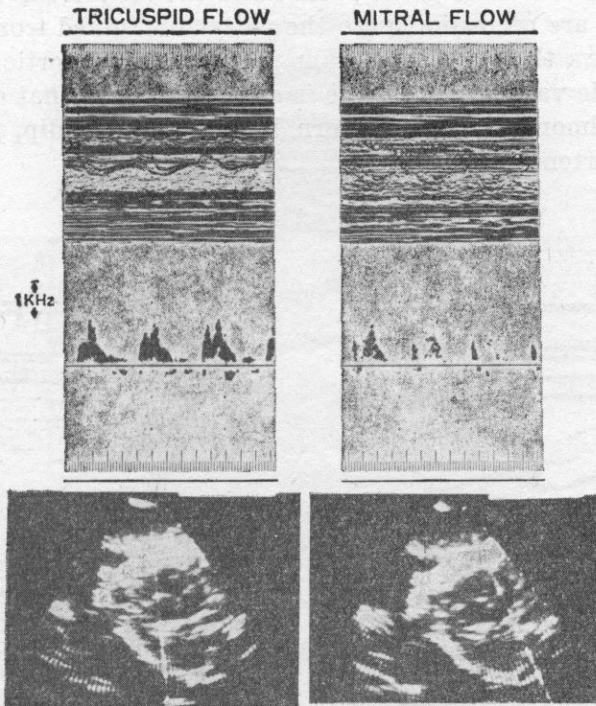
Doppler spectrum
